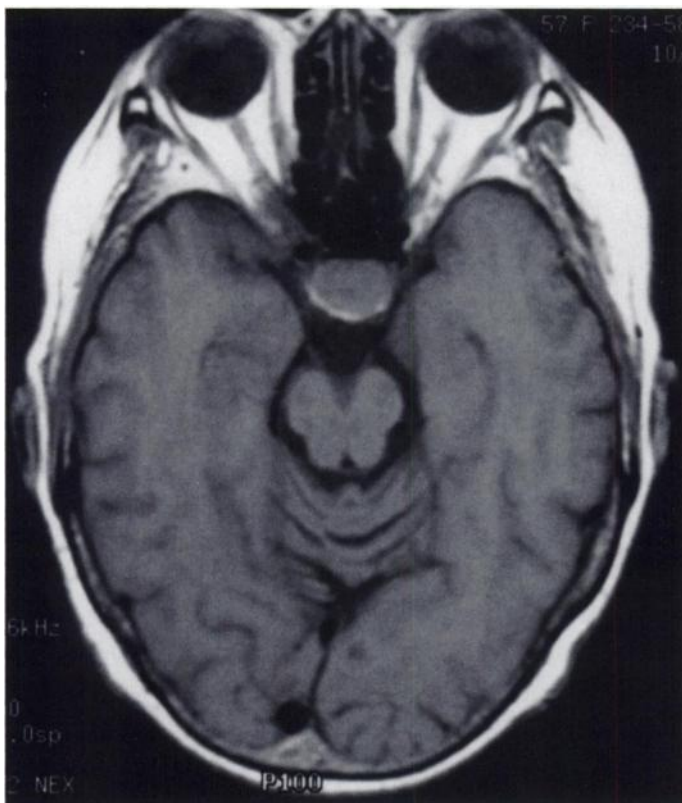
MRI transaxial image showing a 1.5 × 2.0 cm suprasellar mass consistent with a pituitary prolactinoma.
